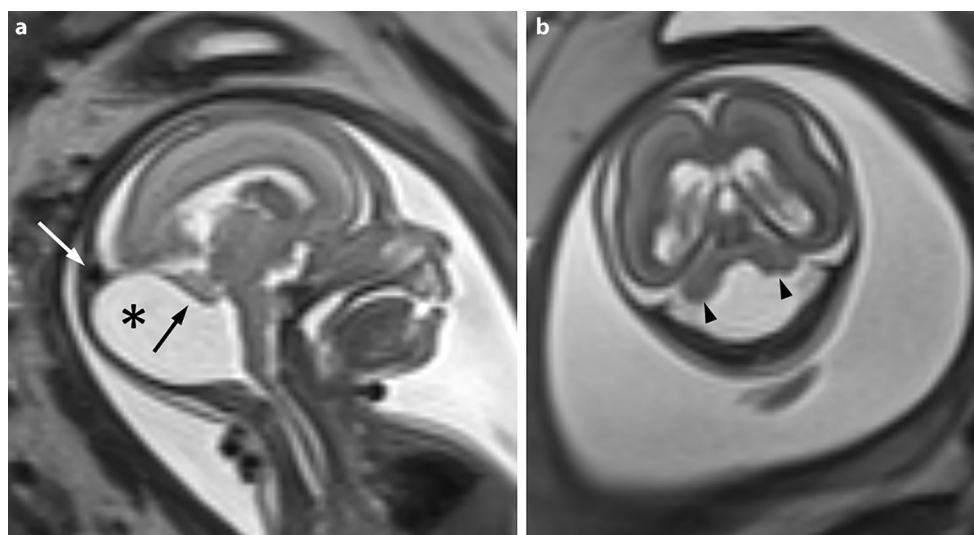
a–d Fetal 3T magnetic resonance imaging at 20 weeks gestation following sonographic suspicion of persistent Blake’s pouch. Thickened, elongated, and horizontally orientated superior cerebellar peduncles (a, arrows) compatible with “molar tooth sign”, roughly normal cerebellar hemispheres (b, arrowheads), an enlarged posterior fossa (c, asterisk), and a hypoplastic, moderately elevated vermis (c, arrow) are shown in axial (a, b) and sagittal (c) HASTE images. The association with enlarged polycystic kidneys (d, asterisks), as depicted on a coronal HASTE image, suggests a cerebellorenal phenotype within the Joubert syndrome spectrum
